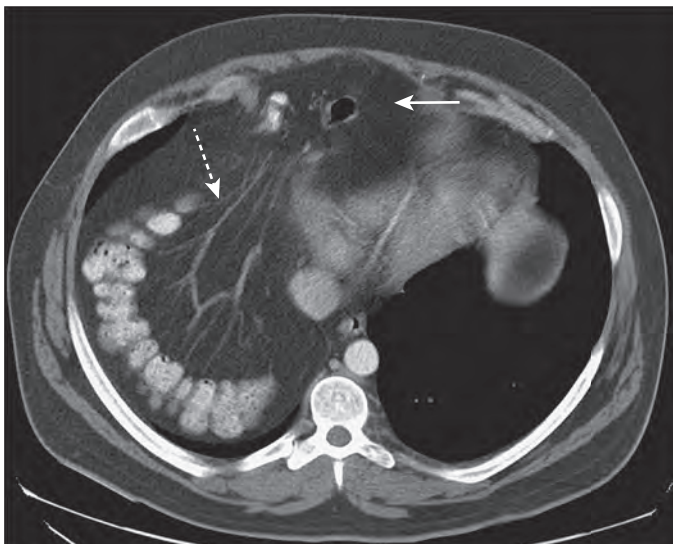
Foramen of Morgagni hernia. CT scan shows a retrosternal hernia that includes the omentum and colon (arrow). Notice the fanlike disposition of the mesenteric vessels (dashed arrow).
